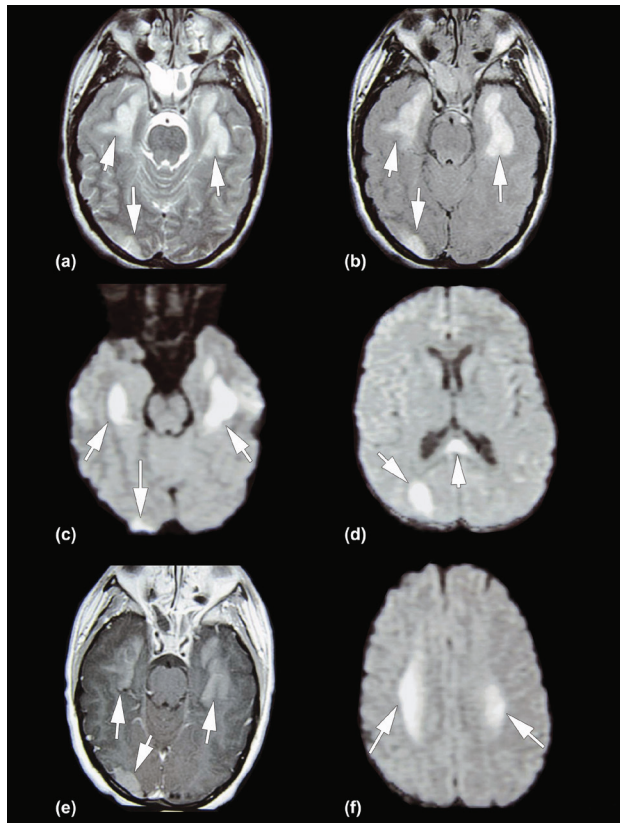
Initial MRI: (a) Axial T2-weighted image, (b) Axial FLAIR image: hyperintensity in the temporal lobes and an area of hyperintensity in the right occipital lobe. (c) Axial DWI reveals restricted diffusion bilaterally in the temporal lobes and right occipital lobe, in the right occipital lobe and splenium (d) and in the centrum semiovale (f). (e) Contrast-enhanced axial T1W image demonstrates enhancement bilaterally in the temporal lobes and right occipital lobe (corresponding areas with arrows).
